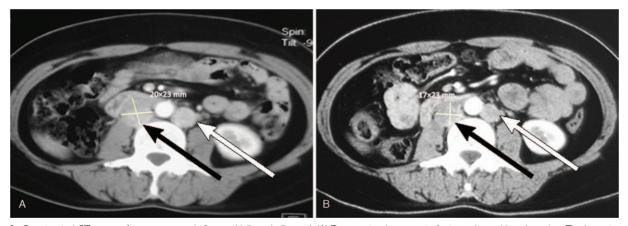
Constructed CT scans of recurrence and after sunitinib rechallenged. (A) Recurrent enlargement of retroperitoneal lymph nodes. The largest one was 20×23 mm (red arrow), another obvious one between aorta and left renal vein (blue arrow). (B) Contrasted CT scan after 2 cycles of regaining sunitinib with 2/1 schedule showed small shrinkage of the tumor, indicating stable disease (SD) was achieved. SD=stable disease.
